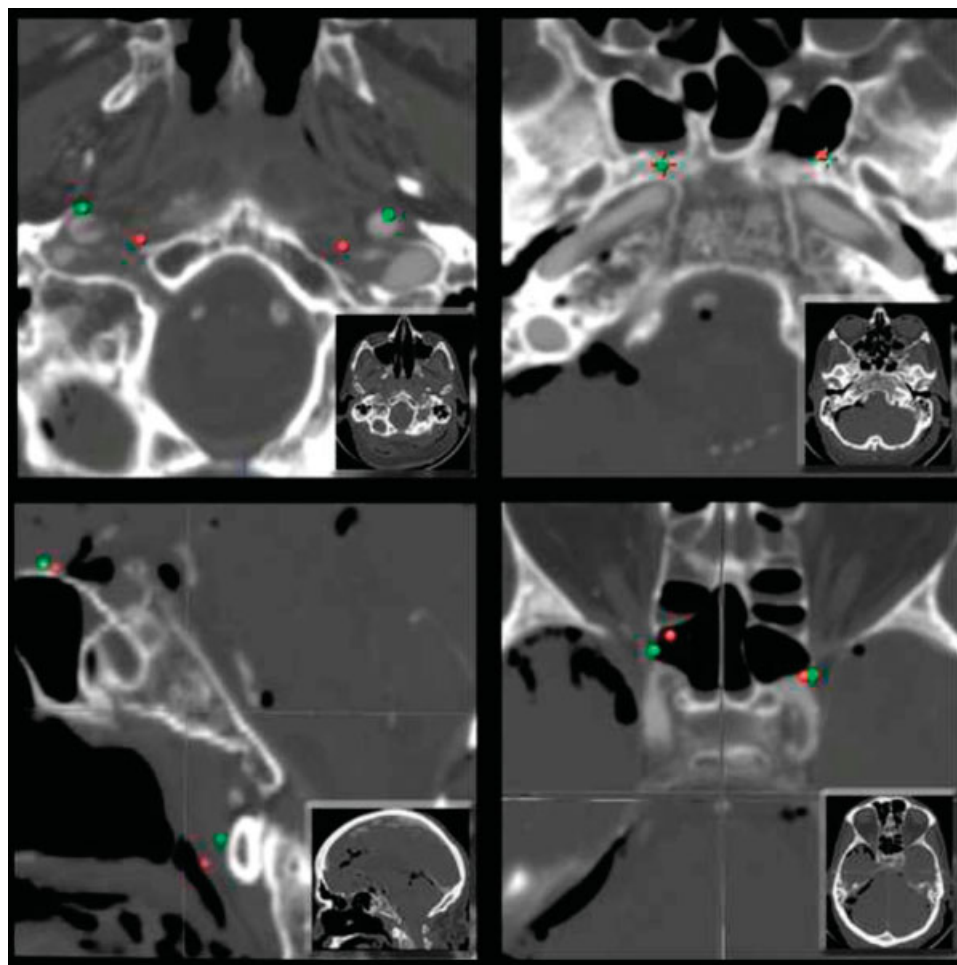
Computed tomography scans comparing the extent of exposure by the expanded endoscopic endonasal approach (red dot) and Le Fort I osteotomy (green dot) approaches; each inset shows level of cut. Upper left, axial scan showing horizontal exposure at the level of hypoglossal canal. Upper right, axial scan showing horizontal exposure at the level of foramen lacerum. Lower left, midsagittal scan showing vertical extension. Lower right, axial view showing horizontal exposure at the level of the opticocarotid recess.
